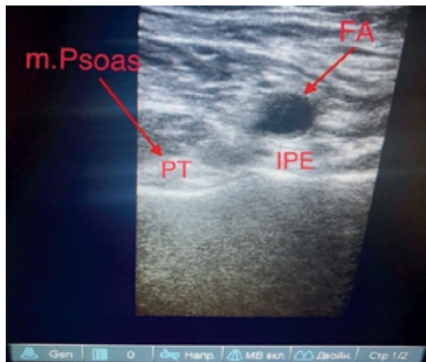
Ultrasound landmarks for regional anesthesia of nerve groups innervating the capsule of the hip joint using a linear transducer
